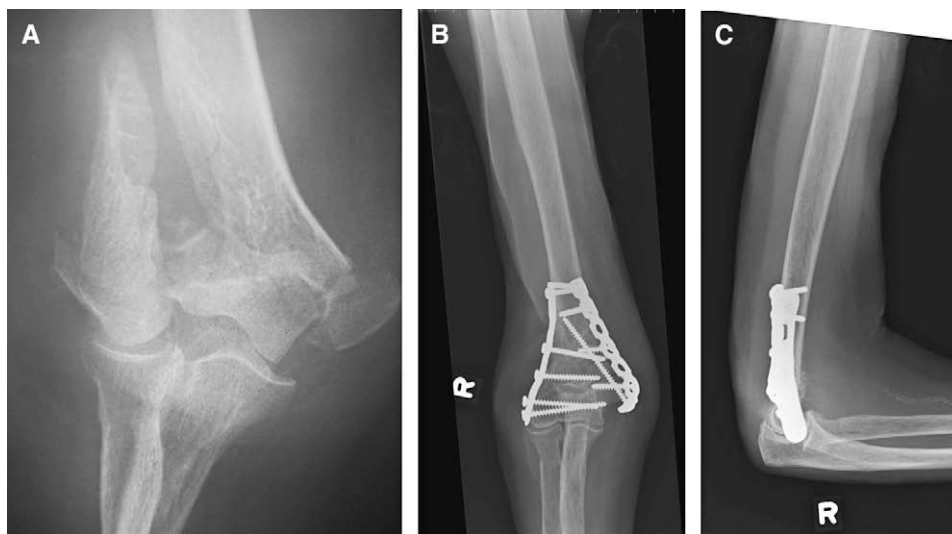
Preoperative radiograph (A) of displaced, comminuted, intra-articular distal humeral fracture in an 84-year-old woman and anteroposterior (B) and lateral (C) radiographs after fixation with a precontoured lateral J plate and a medial pelvic reconstruction plate.
